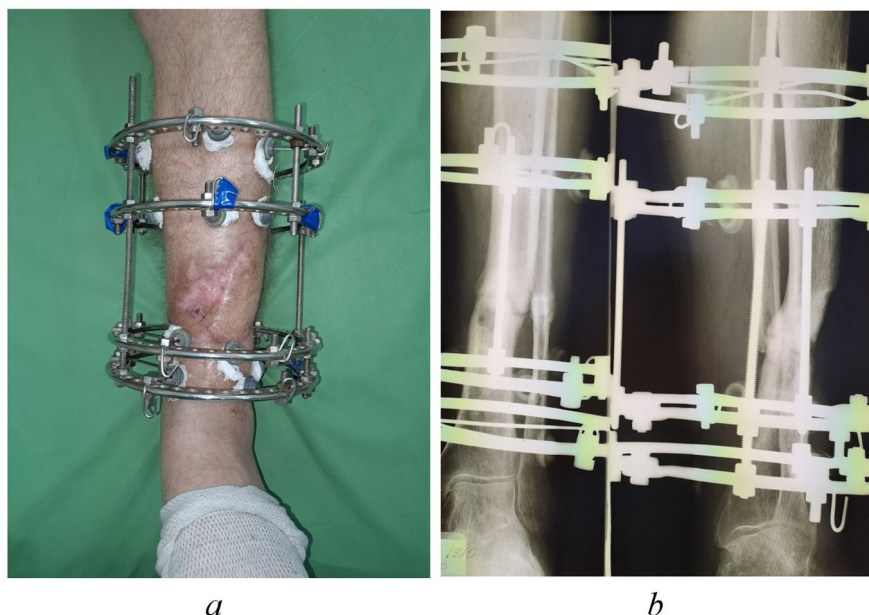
Clinical appearance (a) and radiographic image (b) of the left shin in patient Yu., 43 years old, at 5-month postoperative follow-up
